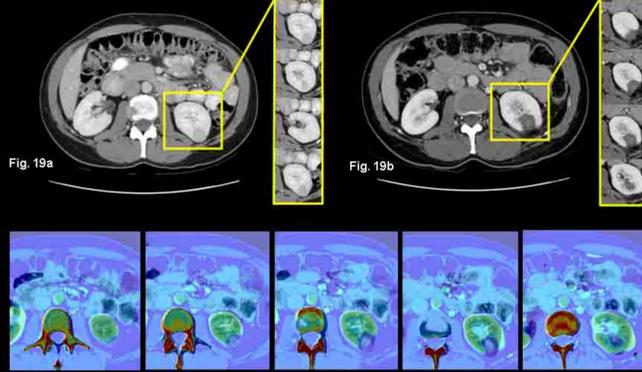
Pre and post CT scans as well as image fusion to define margins. Fig. 17: Fusion of surface displays (pre and post CT) shows 3D relation of tumor to treatment margins. Fig. 18: CT - PET fusion diagnoses residual tumor (RT) after RFA which could be visualized by surface rendering based on CT data (Fig. 17).
